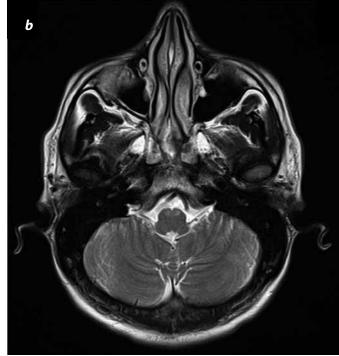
Twenty-eight-year old patient presenting with sudden neurologic decline. a) Coronal FLAIR sequence of the brain showing hyperintensity in the bulbo-medullary junction. b) Axial image with T2 information in the bulbo-medullary junction with anterior hyperintensity related to myelopathy due to acute disseminated encephalopathy.
